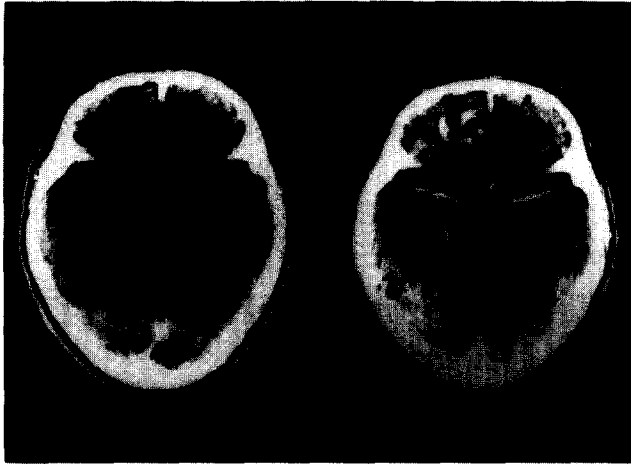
Repeated CT scans from Patient 1. The contrast-enhancing CT scan shows ill-bordered hypodense areas in the right frontal lobe at the time of the first PET examination (left image). Four years and 5 months after the initial diagnosis, a modestly contrast-enhancing mass, with calcification, emerged from the same region (right image).
